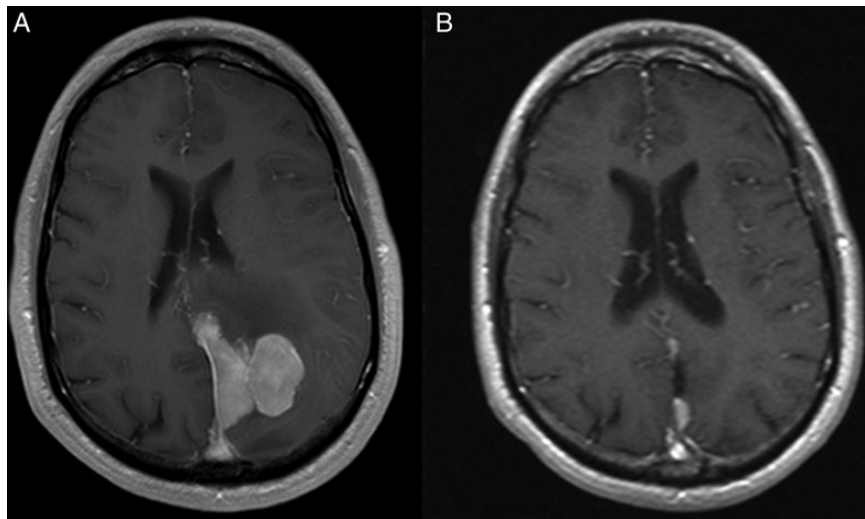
(A) Preoperative and (B) postoperative, postgadolinium T1-weighted MR images demonstrate extensive subtotal resection of a falcine meningioma.
